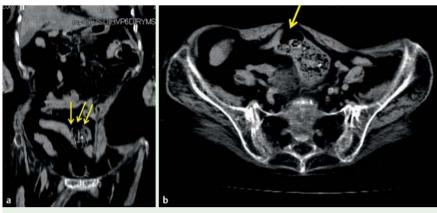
Computed tomography (CT) scan in a 78-year-old woman who had undergone emergency open surgery 7 days previously, involving resection of the descending colon, creation of a transverse colostomy, and closure of the blind sigmoid colon, showing a suspected leak at the functional anastomotic site of the blind sigmoid (yellow arrows) in: a coronal view; and b axial view.
